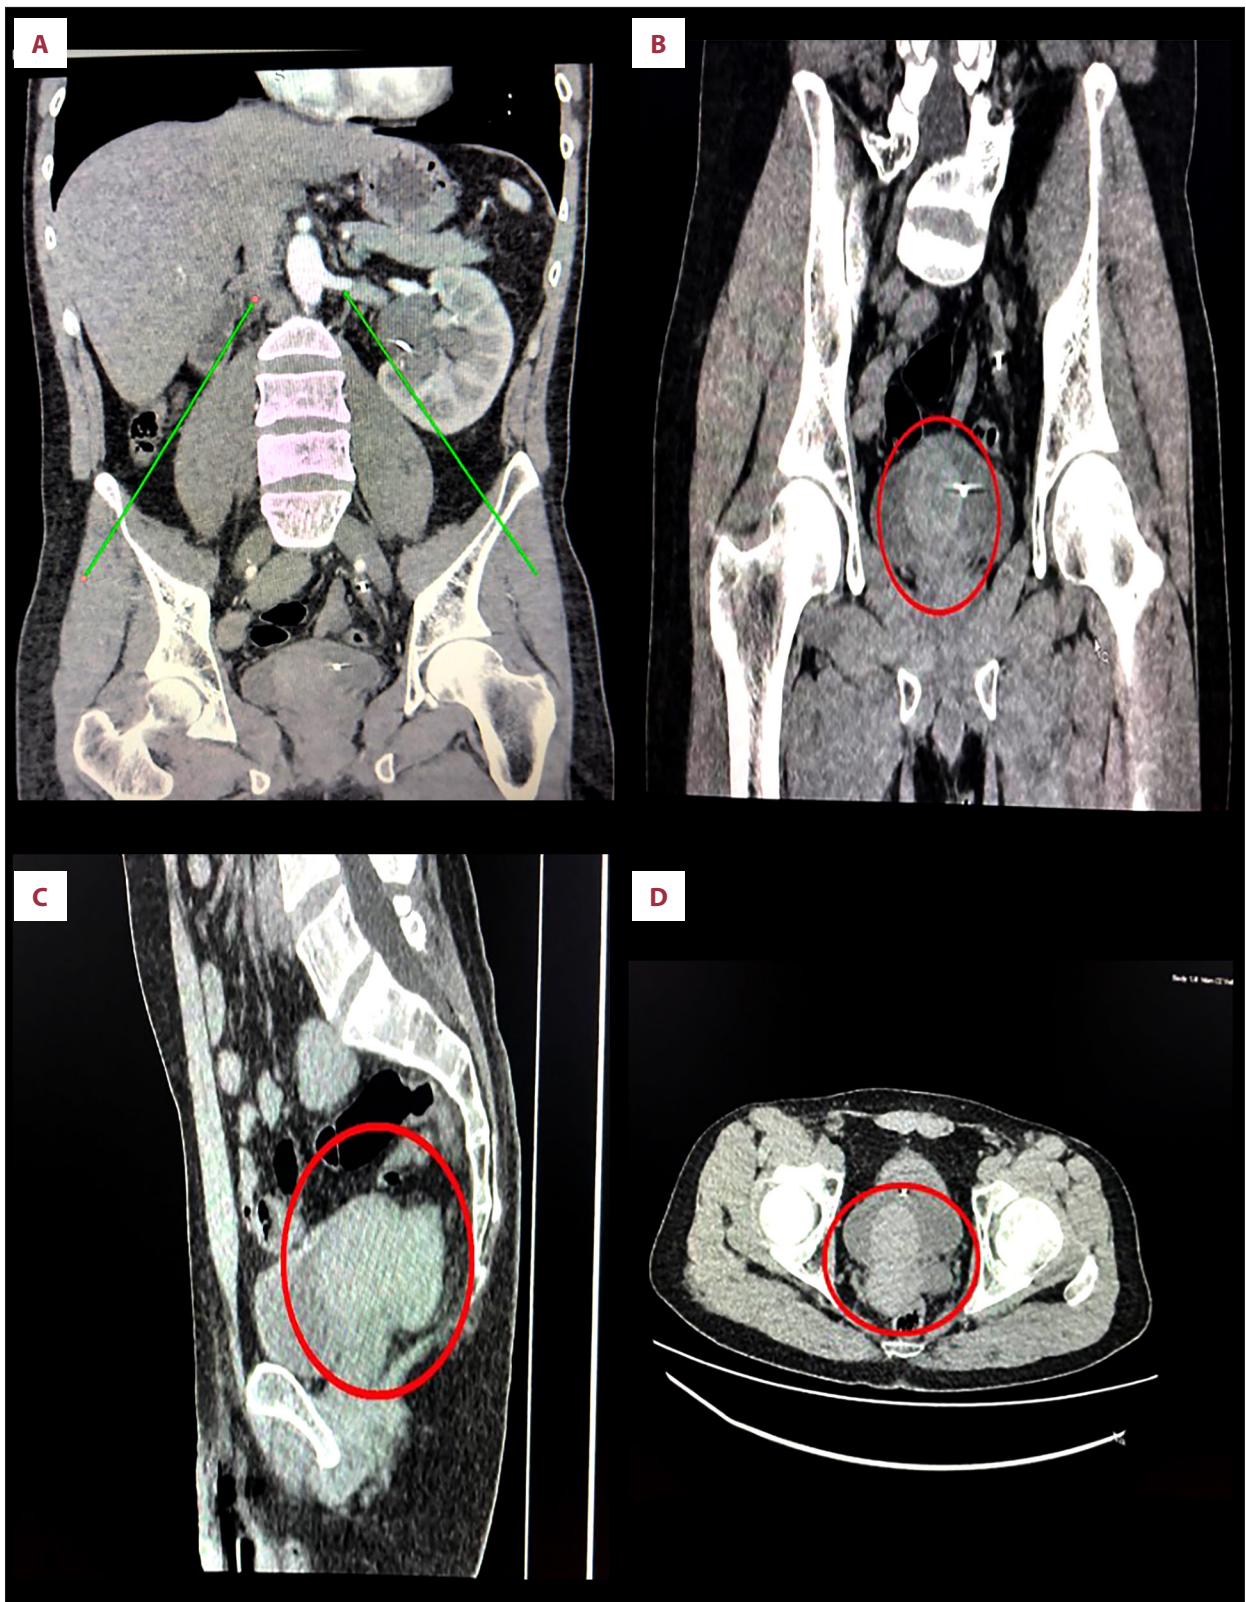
Contrast-enhanced computed tomography of the abdomen and pelvis demonstrating a left seminal vesicle cyst associated with left renal agenesis and left ureteral atresia. The atretic left ureter (A) terminates blindly at the proximal aspect of the cyst (B-D). This constellation of findings represents the classic triad of Zinner syndrome.
